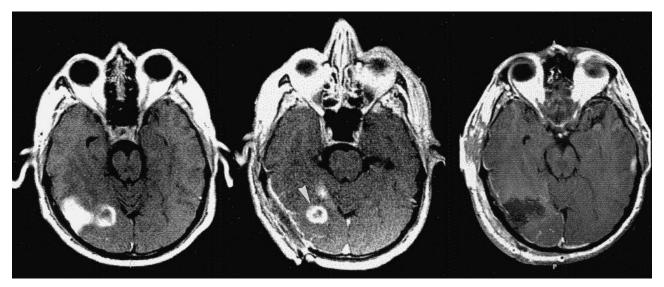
A 55-year-old man with a glioblastoma multiforme. The bulk of the tumor is above the level of these T1-weighted images. Left, Preoperative MR image shows a right-hemispheric lesion (674/20/2).
